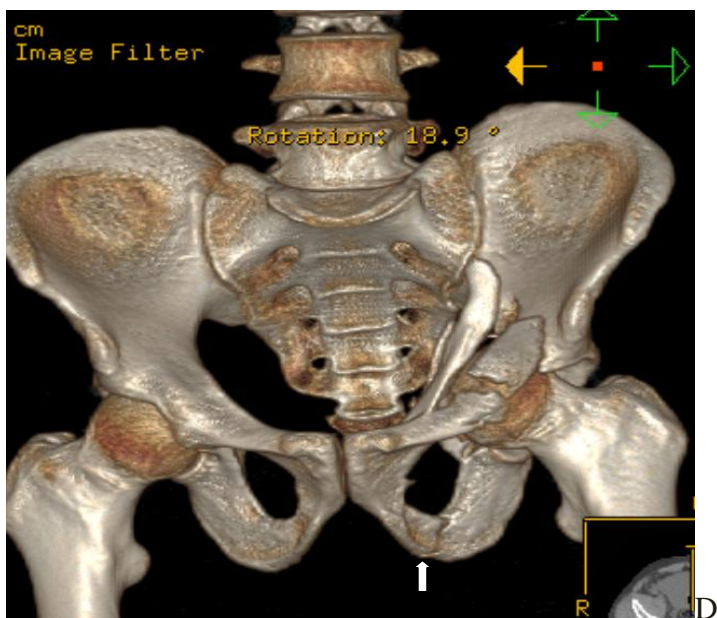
Left anterior column acetabular fracture with central hip dislocation. Coronal (A), Axial (B) , sagittal (c) and 3-D (D) Pelvic computed tomography (CT) scan of a 38 years old male patient shows oblique fracture line the left anterior column which separates it from sciatic buttress. There is also comminuted and displaced fracture of the quadrilateral plate (best depicted on axial and 3-D images) with central femoral head dislocation. Associated left anterior wall acetabular fracture also noted (C, double arrow). Fracture of the left superior pubic ramus at its root and left inferior pubic ramus at its mid portion (D, white arrow) also seen.
